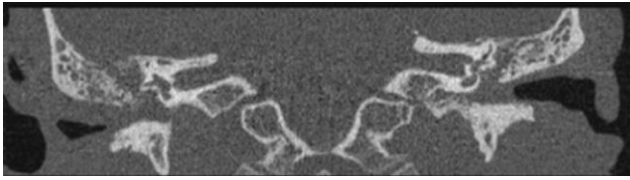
Axial & Coronal view of HRCT petrous showing bilateral middle ear cavity and mastoid air cells soft tissue density and fluid, right External Ear Canal (EAC) stenosis with erosion of right ossicular chain mastoid air cells, posterior EAC wall, tegmen tympani and sigmoid plate dehiscence. (white arrow)
